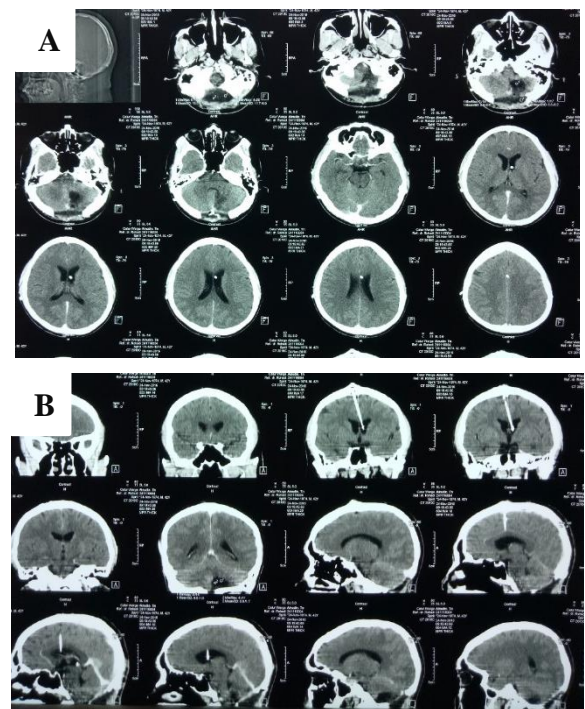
Head CT scan with contrast. A) Axial section. B) Coronal-sagittal section: ventricular size diminished in a case and encephalomalacia in infarct area.
